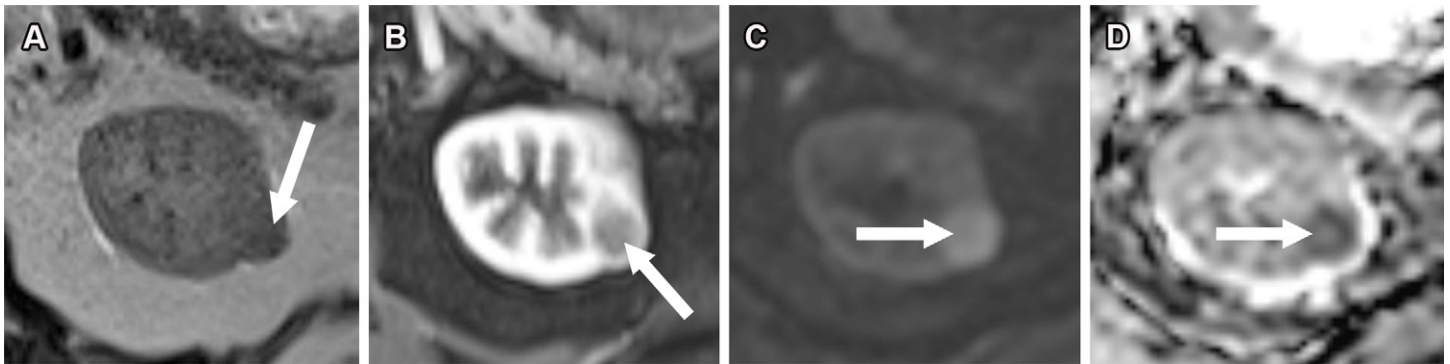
pRCC initially incidentally identified at MRI of the spine in a 67-year-old man. (A) Axial T2-weighted MR image shows a T2-hypointense 1.5-cm left renal mass (arrow). (B) Axial postcontrast CMP T1-weighted MR image shows mild enhancement of the mass (arrow). (C, D) Axial diffusion-weighted MR image (C; b value = 800 sec/mm²) shows marked hyperintensity (arrow), and axial ADC map (D) shows corresponding hypointensity (arrow). The ccLS is 1 (very unlikely to be ccRCC), with the primary consideration being pRCC, although fpAML can rarely have this appearance.
